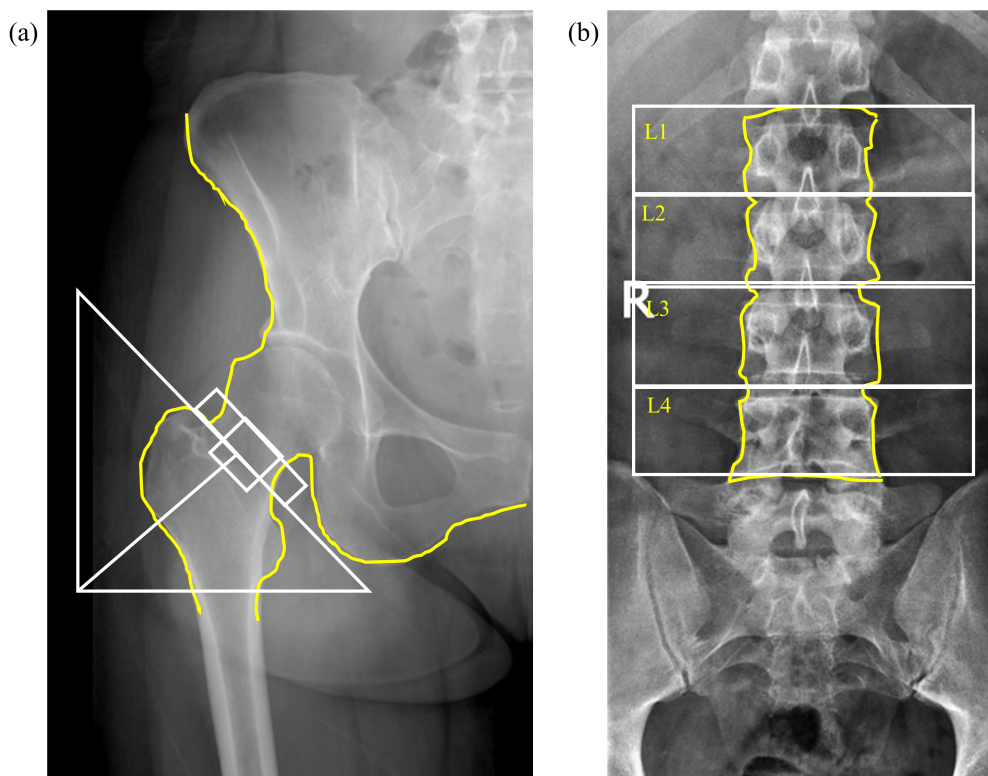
Bone mineral density location at X-ray at the (a) femoral neck and (b) lumbar spine 1–4.
